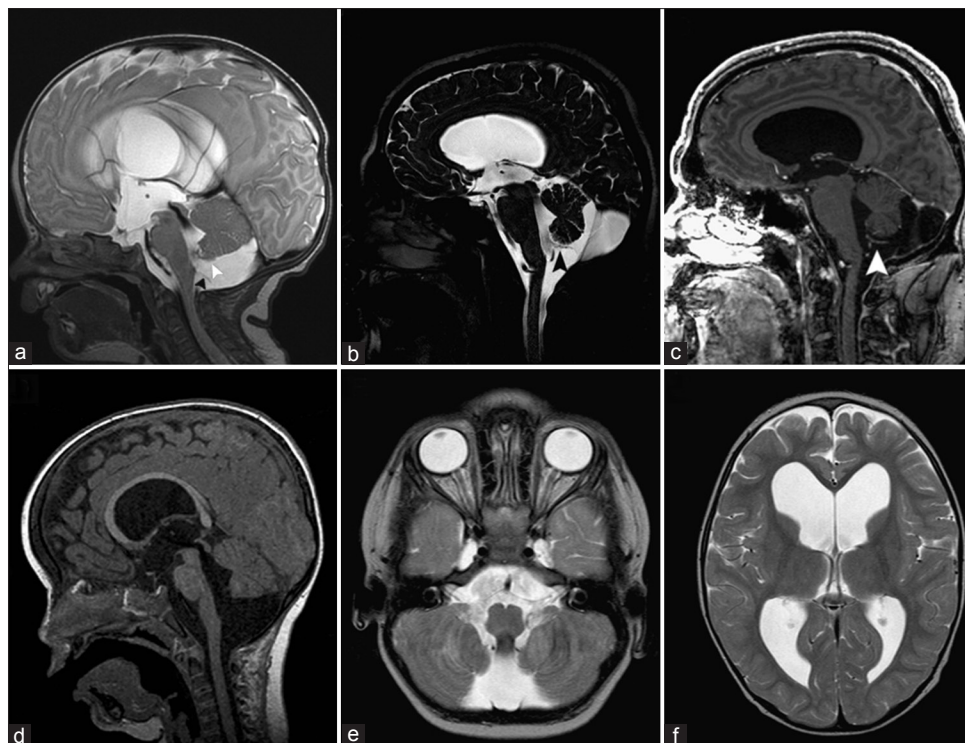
(a) Sagittal T2-weighted MRI image in a case with Blake's pouch cyst. Note the infracerebellar position of the cyst with compressed nonrotated relatively intact cerebellar vermis. The continuation of the fourth ventricular choroid plexus into the Blake's pouch cyst (white arrowhead) and the thin membrane demarcating the cyst from subarachnoid space (black arrowhead) are evident. (b, c) Images from one case reported by Cornips *et al.* 2011^[10] demonstrating similar findings. (d-f) Another case from Cornips *et al.* 2011;^[10] (d) Preoperative sagittal T1-weighted MR image demonstrating marked hydrocephalus with bulging third ventricular floor, downward bending mammillary bodies, and an open aqueduct. The cerebellum is not rotated. (e) Preoperative axial T2-weighted MR image demonstrating a bilateral indentation on the caudomedial cerebellar surface. (f) Preoperative axial T2-weighted MR image demonstrating enlarged lateral ventricles without periventricular hyperintensities
